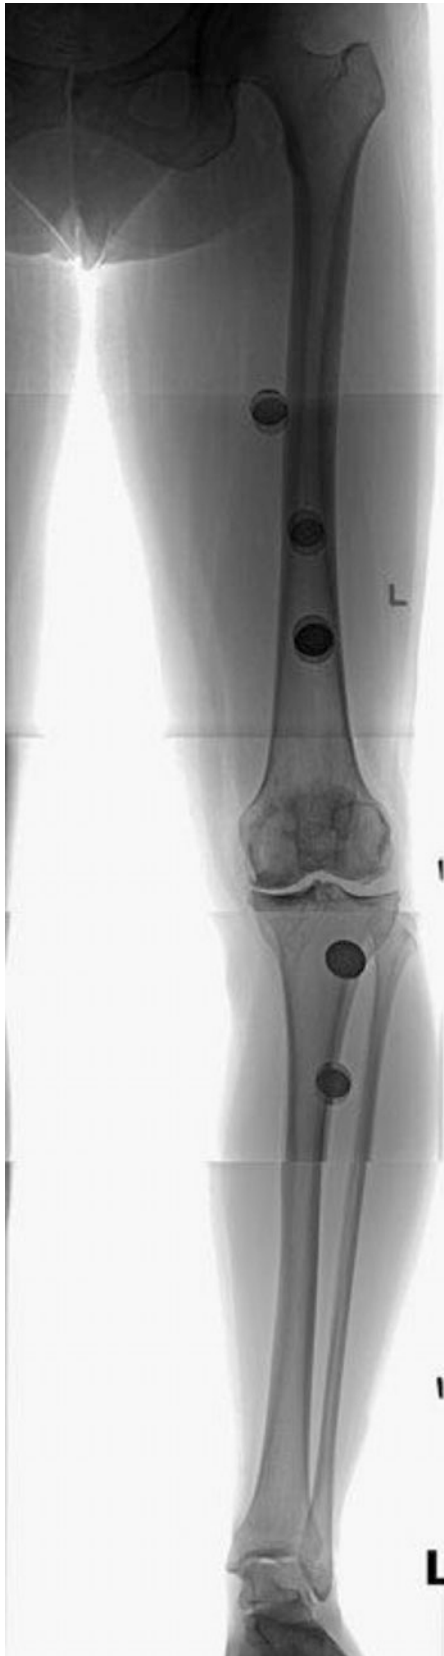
Three-foot standing X-ray of a failed ACL reconstruction from varus malalignment
